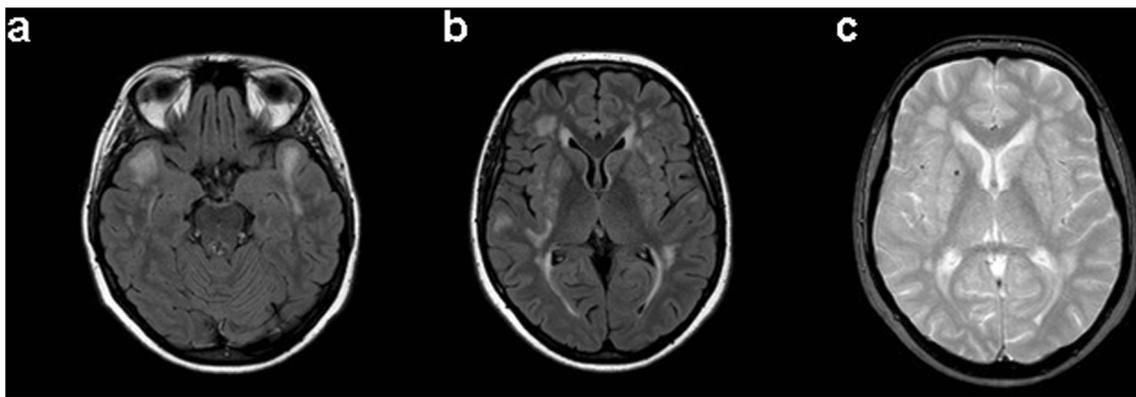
Brain MRI images of the proband. a, b Axial long TR weighted images: multiple symmetrical hyperintensities in the periventricular and subcortical white matter, more evident in the subcortical anterior temporal
